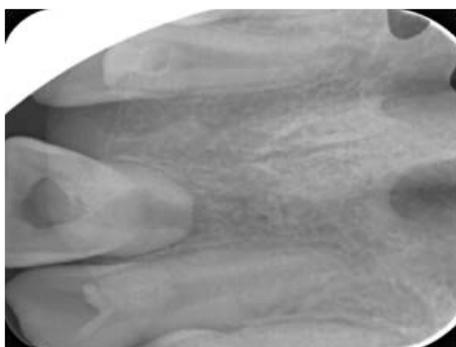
Radiographic view of case 2
